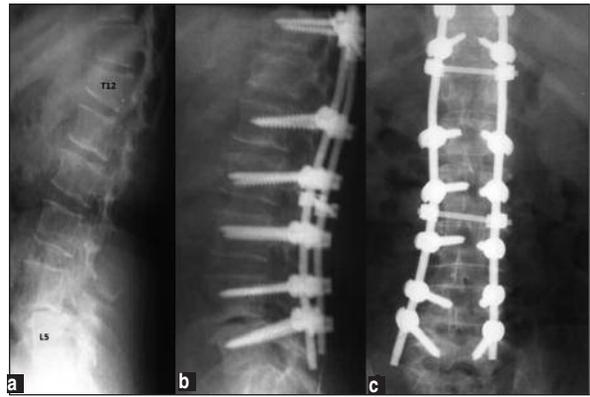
Lateral lumbar x-ray (a) is showing a compressed fracture in the 12th thoracic vertebra which is anteriorly narrowed in a wedge shape and L4-L5 degenerative spondylolisthesis. Postoperative sagittal (b) and posteroanterior (c) lumbar x-rays demonstrating good correction of spondylolisthesis and good placement of instrumentation.
